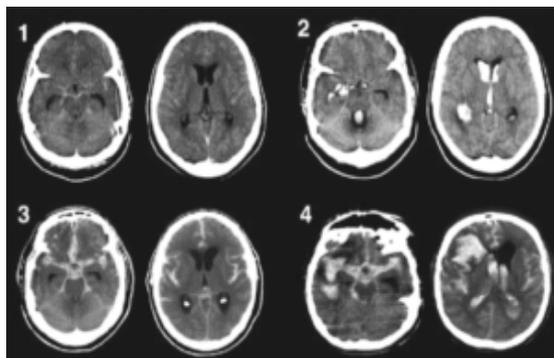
Modified Fisher CT Grading Scale
